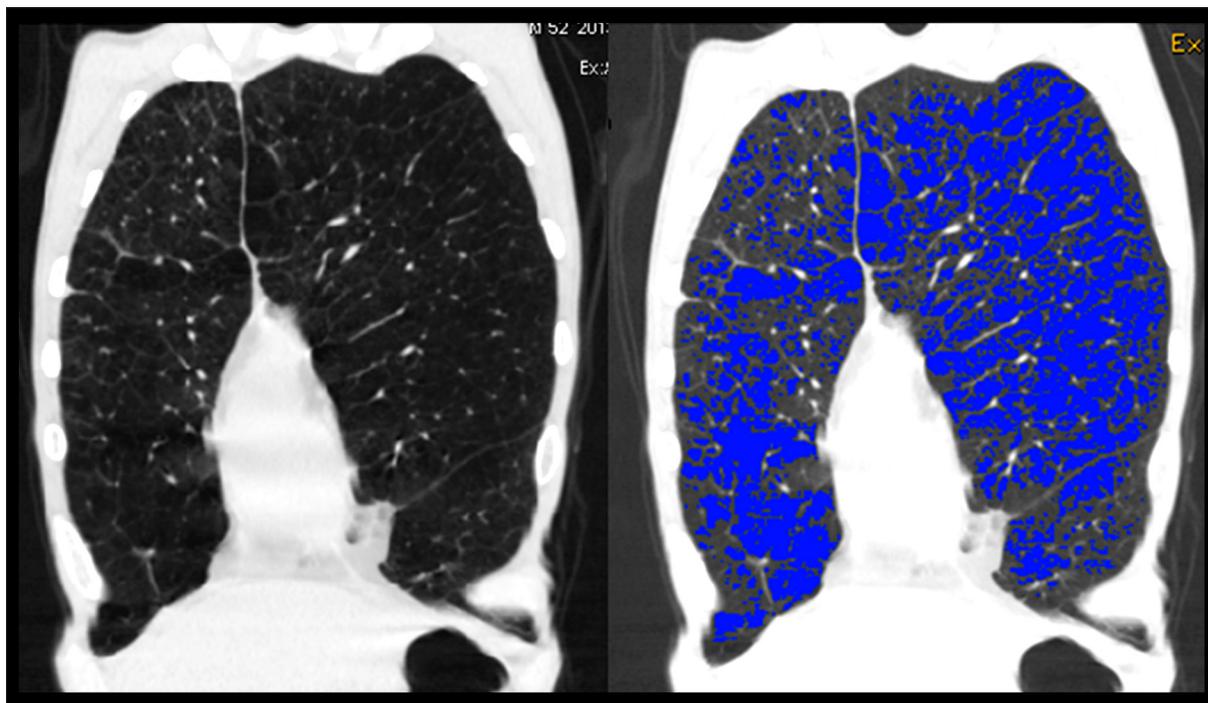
Comparative assessment of non-color-coded and color-coded HRCT images in severe COPD.
